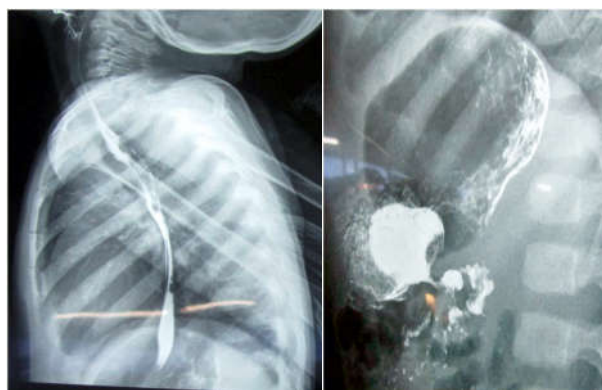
Upper gastrointestinal contrast X-rays (Lateral and Antero-posterior) of a patient showing partial Gastric Outlet Obstruction.
